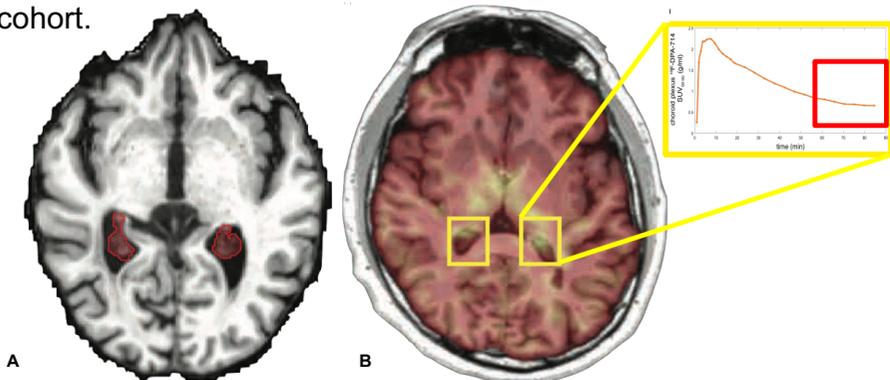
CP segmentation on the 3DT1 image (A) and SUV extraction (B) from 60 to 90 min.
